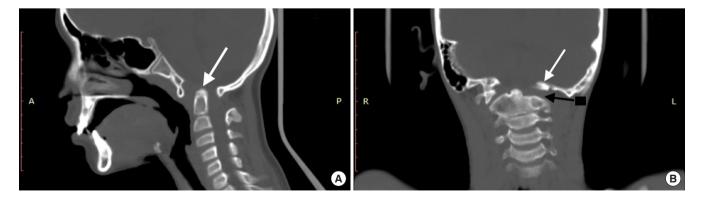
(A) Sagittal computed tomography (CT) showing basilar invagination (white arrow) with atlantoaxial dislocation. (B) Coronal CT showing hypoplastic occipital condyle (white arrow) and aplasia of the lateral mass of atlas on one side (black arrow).
